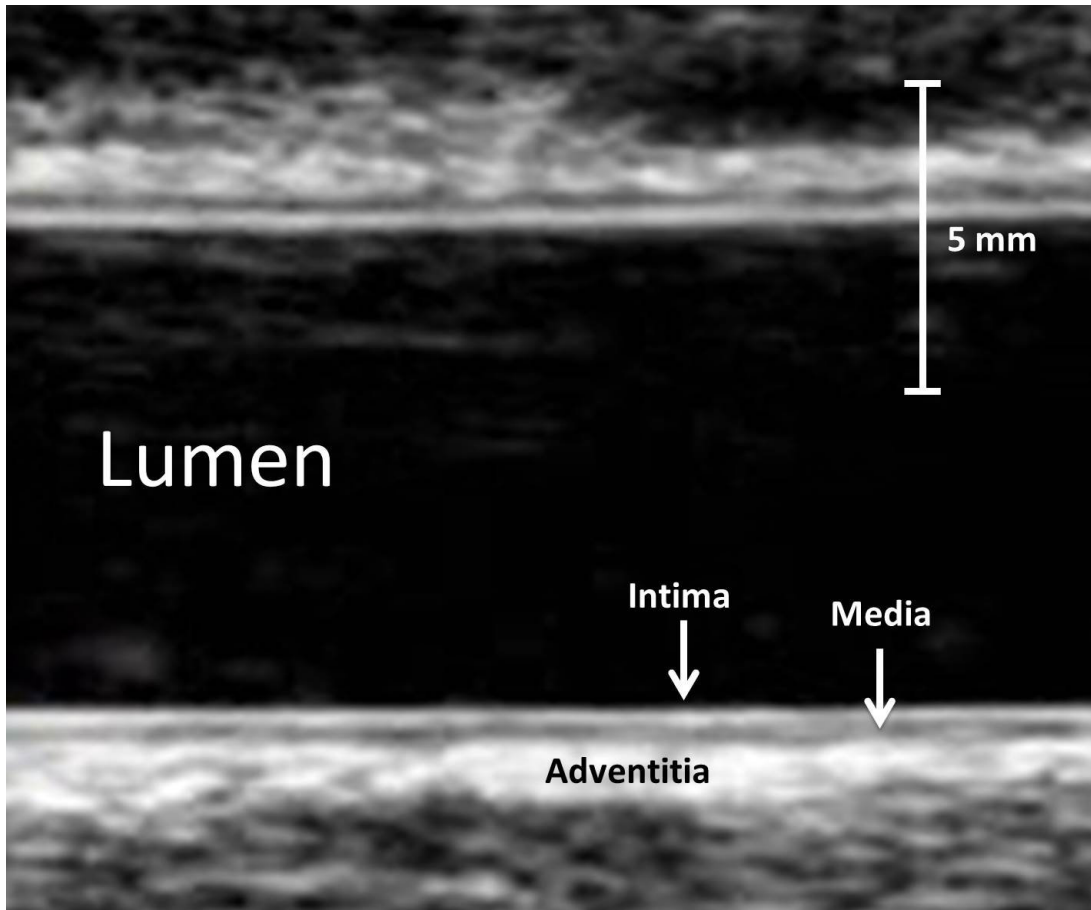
Ultrasound B-mode image of the CA. The image shows the longitudinal section of the CA with the distinct wall reflections of Intima and Media layers. The far wall (bottom) of the vessel is taken for Intima Media Thickness analyses.
